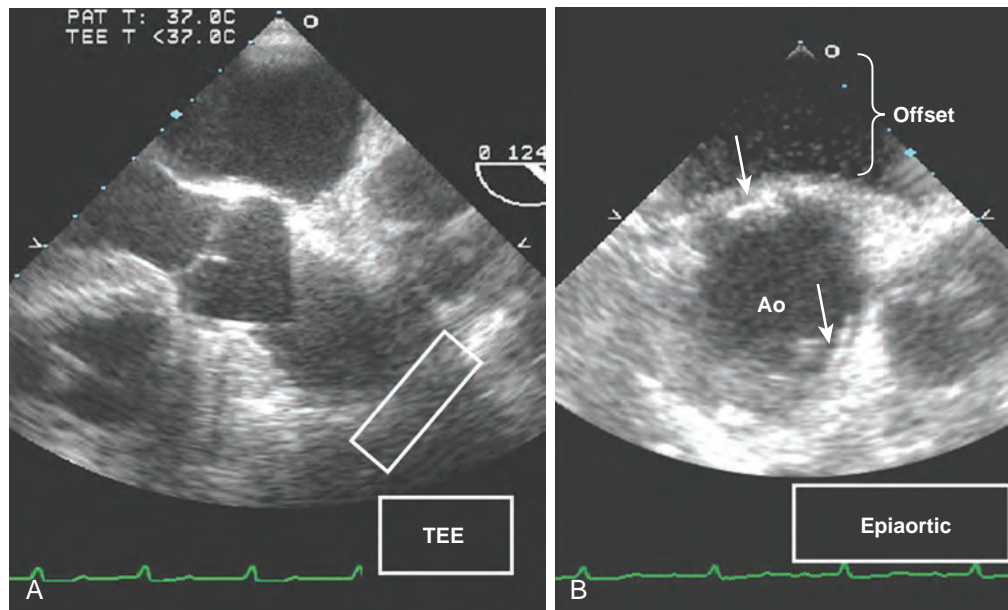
Detection of atheromatous plaque by epiaortic ultrasound. A 67-year-old patient was scheduled to undergo triple coronary artery bypass grafting. Transesophageal echocardiographic (TEE) examination was performed to evaluate the mitral valve for mitral regurgitation that could necessitate surgical intervention. Routine examination of the descending thoracic aorta detected severe atherosclerotic disease characterized by several ulcerated areas and plaques with a thickness of 4 mm. Because the severity of atherosclerotic disease in the descending aorta predicts significant disease in the ascending aorta,¹²⁷ examination of the ascending aorta was attempted. (A) TEE examination of the ascending aorta at the site of aortic cross-clamp and cannulation (white rectangle) was limited by poor resolution in the far field and interposition of the trachea. (B) A handheld probe that was placed in a sterile sleeve was used to examine the aorta. The bottom of the sleeve was filled with saline solution as an offset to image the anterior surface of the aorta (Ao) more clearly. Several calcified plaques (arrows) were detected. Based on findings of the epiaortic scanning, the surgeon modified the site of cannulation and used a single cross-clamp technique to avoid a second clamping of the aorta during the proximal anastomosis.
